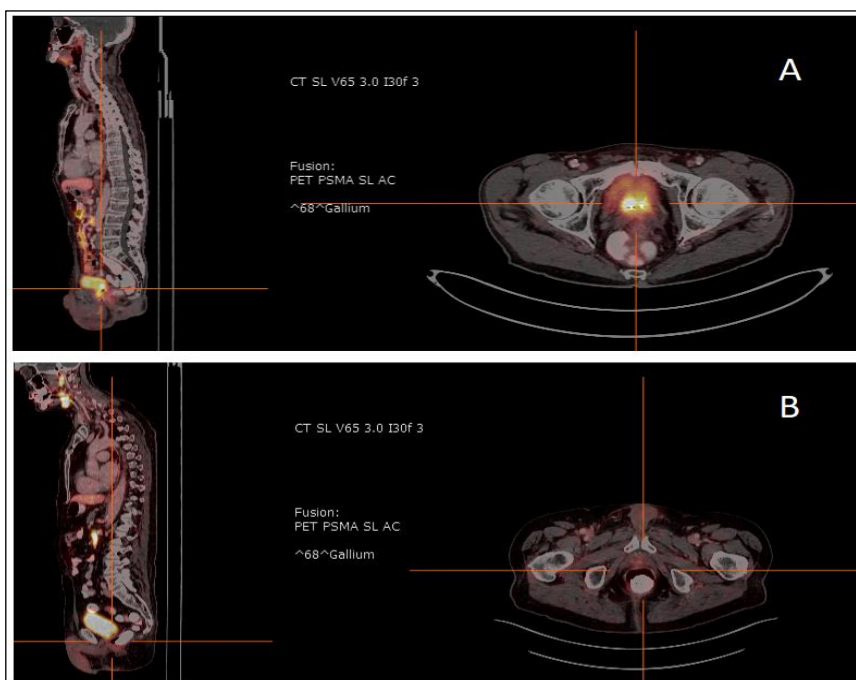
The figure shows two different PET/CT scans (Hermes Hybrid Viewer software, version 5.1.0). The top scan (A) shows a patient who has had a recurrence after a prostatectomy. This can be seen in the highly illuminated tumour lesion. The bottom scan (B) shows a patient who has not had a recurrence after a prostatectomy. Although this is known in the data, this can also be seen in the scan itself.
